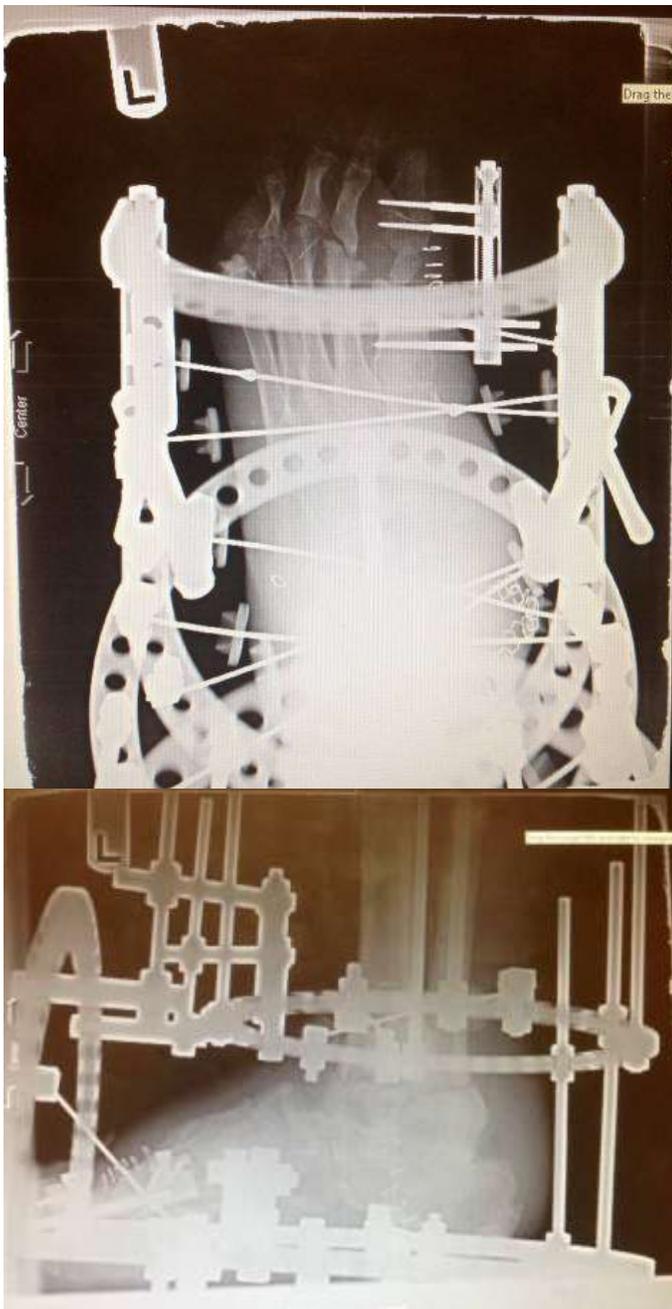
Top: Dorso plantar intra-operative radiograph showing placement of external fixator and monorail. Bottom: Lateral intra-operative radiograph showing placement of external fixator.
